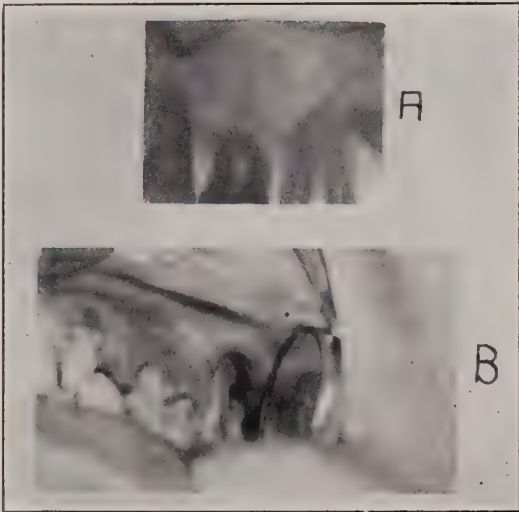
(a) Radiograph of bicuspid and molar teeth fails to show any destruction of bone. (b) Photograph of same teeth showing the absence of the buccal plate of bone about the first molar.
